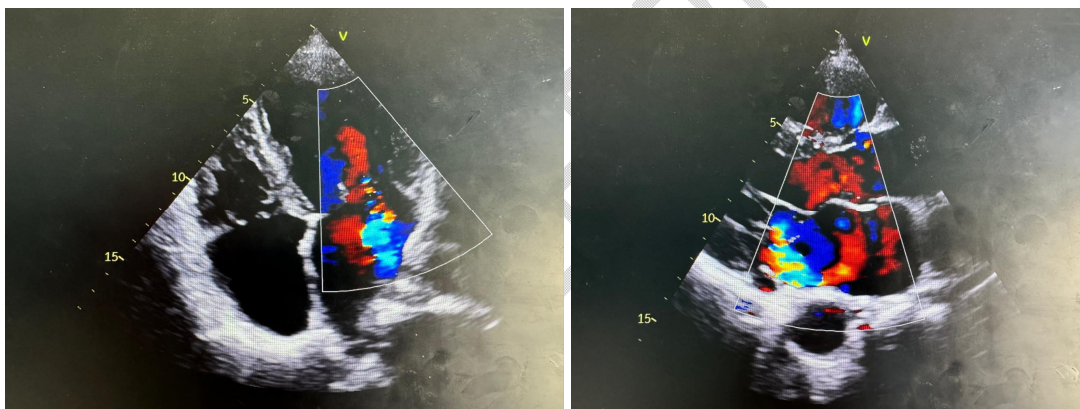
2D Echocardiographic Image with Color Doppler Demonstrating Moderate Mitral Regurgitation.
